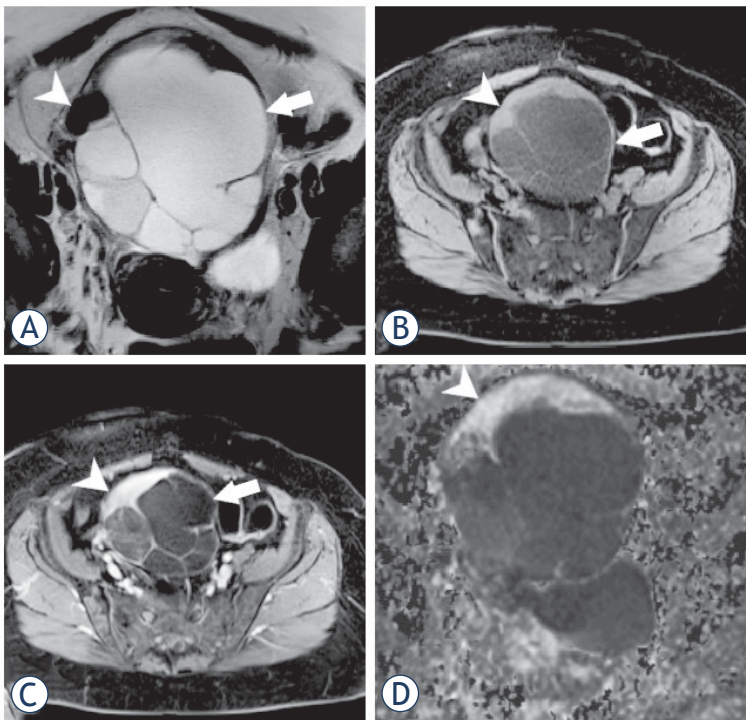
54-year old patient with mucinous cystadenoma (arrow) coexisting with benign Brenner tumor (arrowhead); mucinous cystadenoma has high signal intensity on T2WI (A) and low on T1WI fat sat (B); compared to it Brenner tumor has low signal intensity on T2WI (A) and high on T1WI fat sat (B); on T1 fat sat with contrast (C) only Brenner tumor shows enhancement and on DWI (D) only Brenner tumor shows restricted diffusion.
